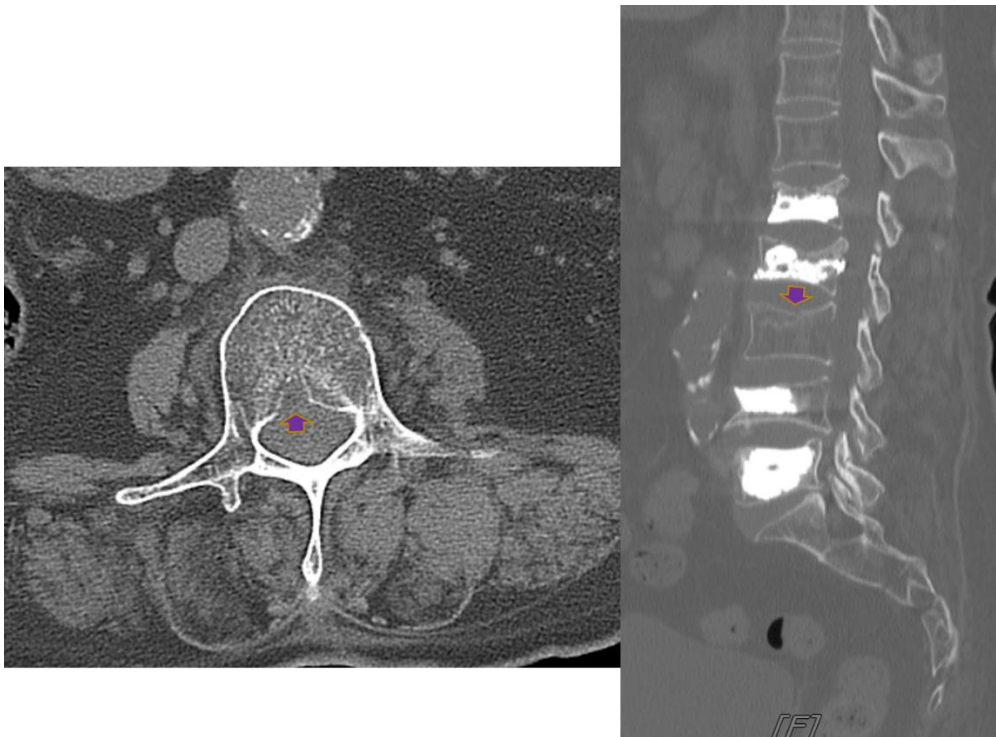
Axial and parasagittal computed tomography images. Newly noted compression fracture at L3 vertebral body (Purple arrow)
